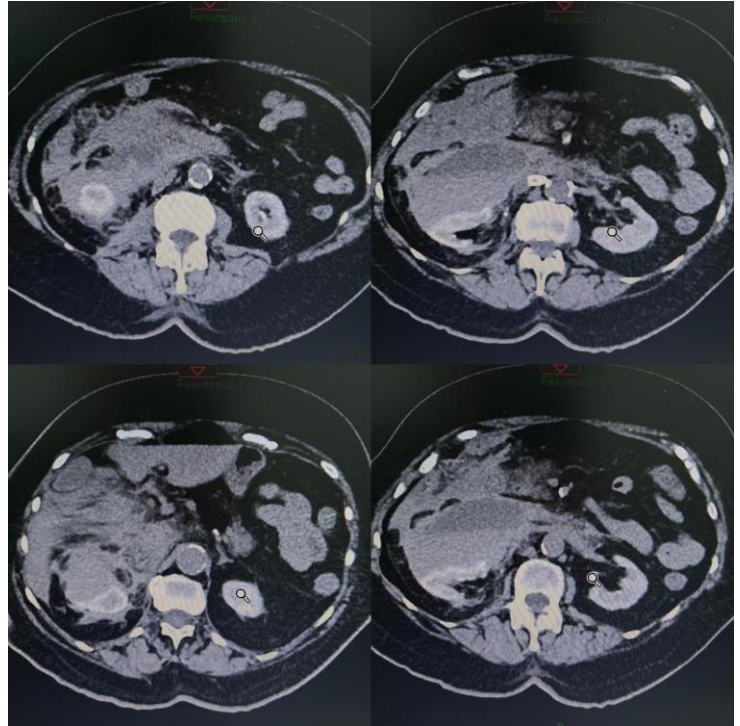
Abdominal Computed Tomography exam exemplifying perirenal hematoma on the right
